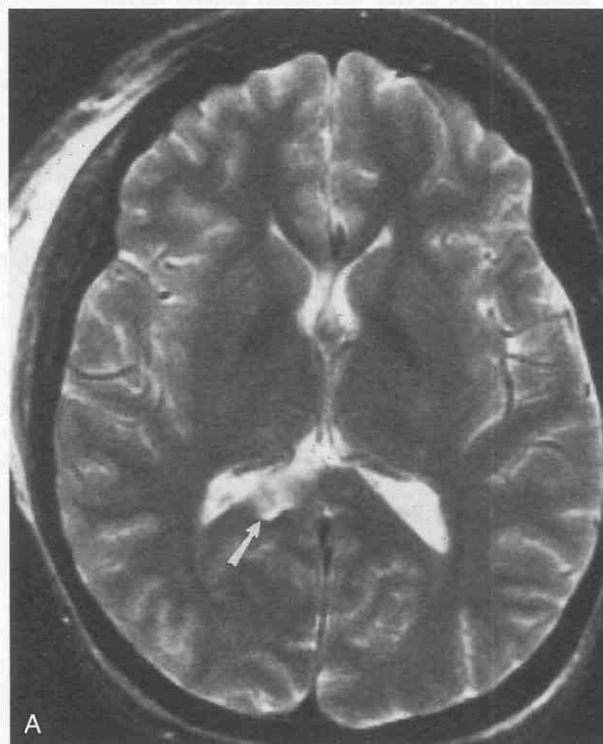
A and B, Diffuse axonal injury in two different patients. Hyperintense lesions are present in the splenium of the corpus callosum on axial T2-weighted (2500/80) MR images (arrows).
